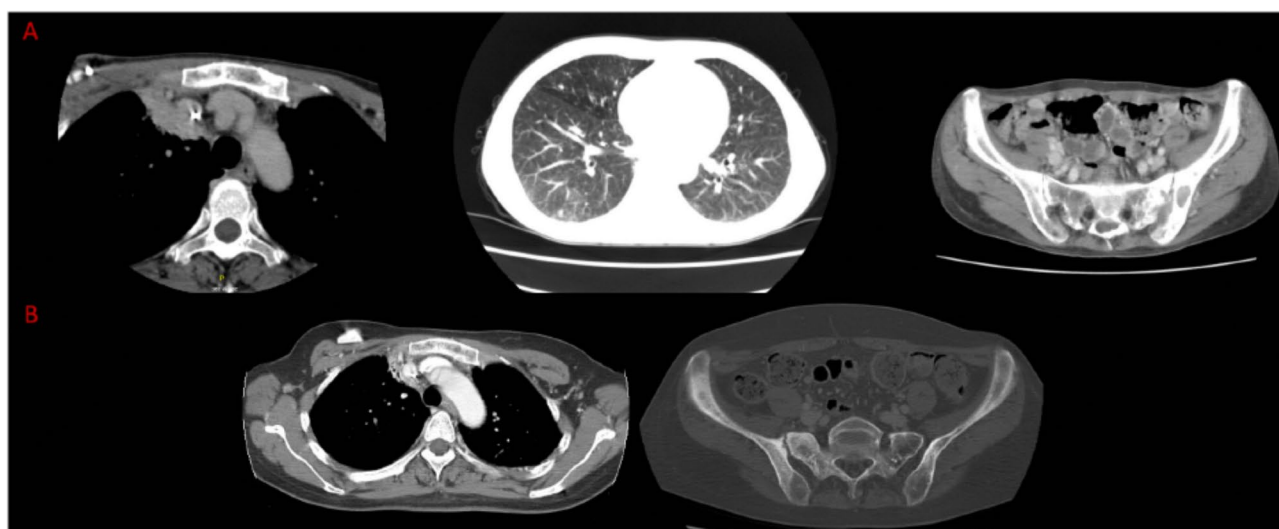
(A) CT scan showing involvement of: right paramediastinal mass (left), lung nodules (middle), lytic lesions of pelvis (right). (B) CT scan showing improvement of: right paramediastinal mass (left), lytic lesions of pelvis (right)
